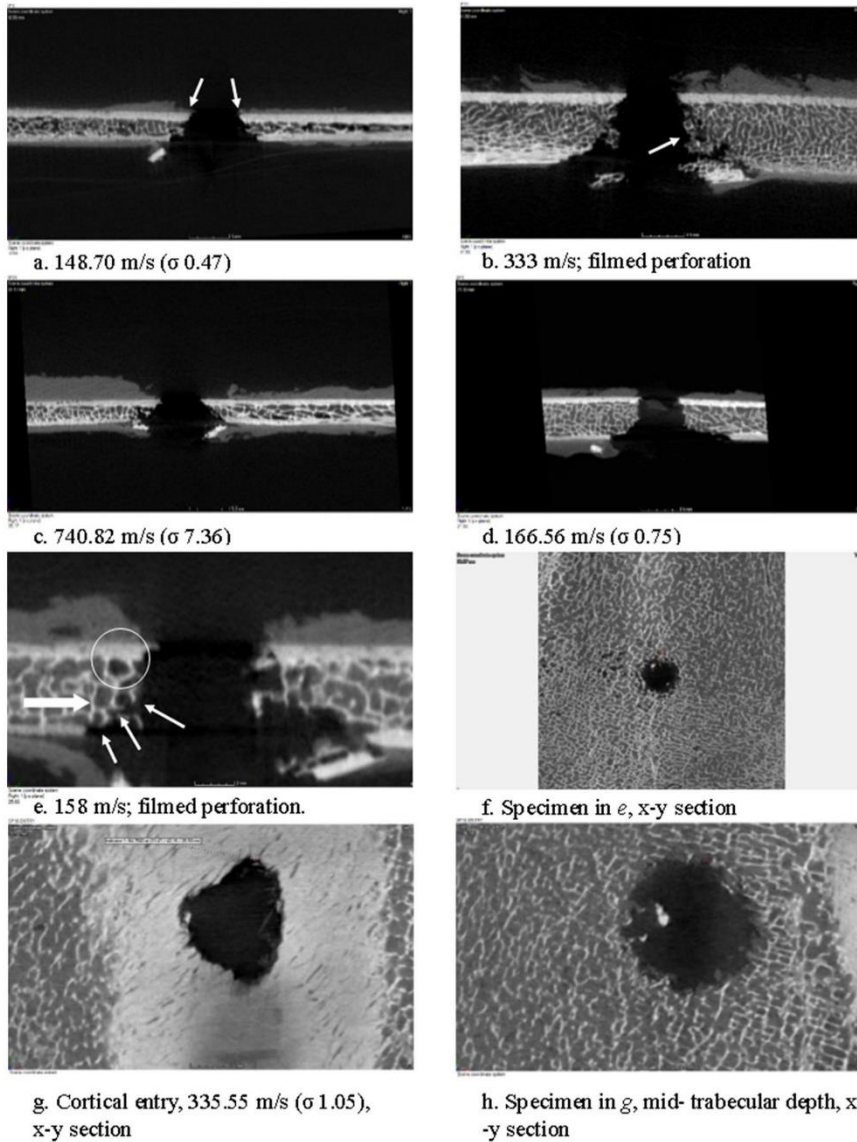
μ -CT cross-sections of projectile wounds. a–c y-z views of conoidal morphology with bilateral angulation of entry cortical fracture edges (highlighted with arrows in a); trabecular intrusion is shown in b (arrow). d y-z section showing atypical wound cross-section. e Fracture morphology consistent with crack propagation one cell width at a time through trabeculae (thin arrows), y-z section. Note bilateral angulation of entry cortical fracture edges, lack of collapse of trabecular cells (thick arrow)
